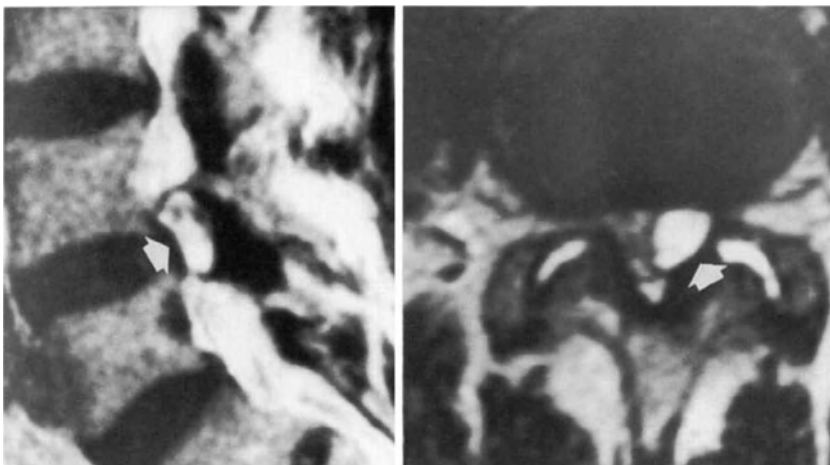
Turbo T2-weighted spin-echo MR images showing a synovial cyst of the left L4-L5 facet joint. An extrathecal lesion with a high signal intensity is visible (arrows), which is in contact with the anteromedial margin of the left facet joint and impinges on the thecal sac. Both zygoapophyseal joints show degenerative changes.
